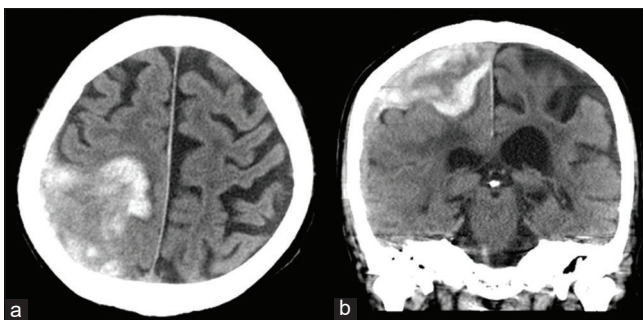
Preoperative axial (a) and coronal (b) computed tomography revealed a right parietal convexity acute subdural hematoma. Retrospective detailed history revealed a meningioma diagnosed 1 year earlier. A tumor was noted at the site of hemorrhage (c-d).
